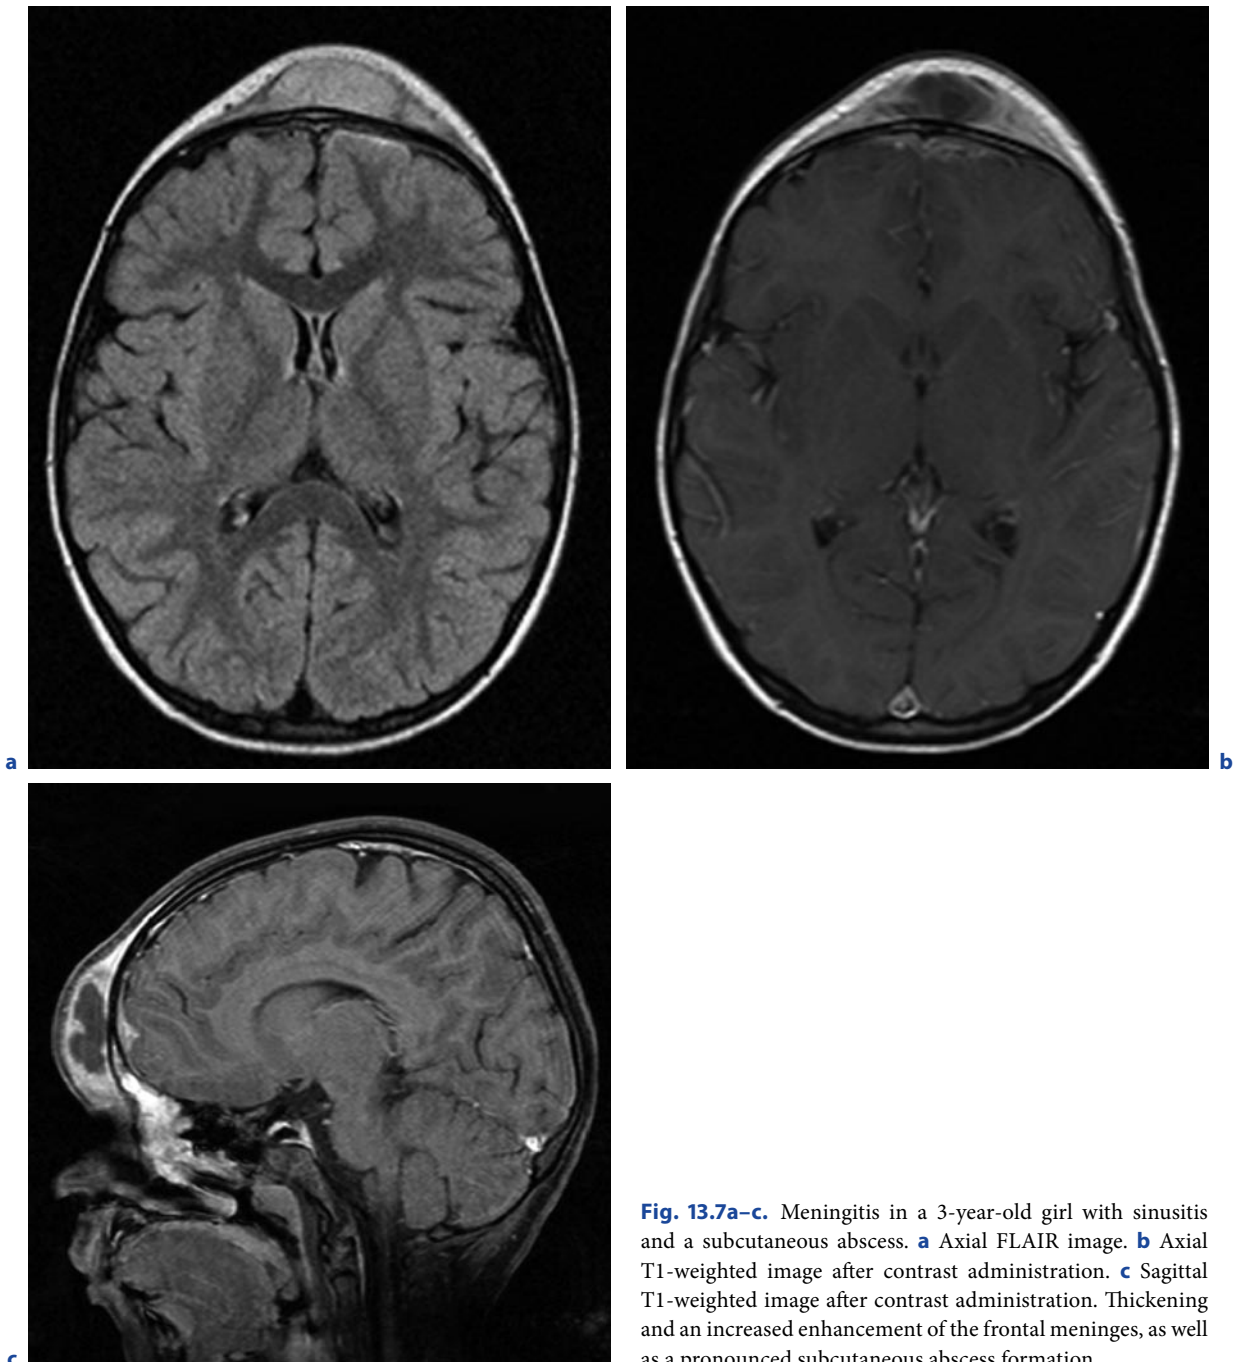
Meningitis in a 3-year-old girl with sinusitis and a subcutaneous abscess. a Axial FLAIR image. b Axial T1-weighted image after contrast administration. c Sagittal T1-weighted image after contrast administration. Thickening and an increased enhancement of the frontal meninges, as well as a pronounced subcutaneous abscess formation
